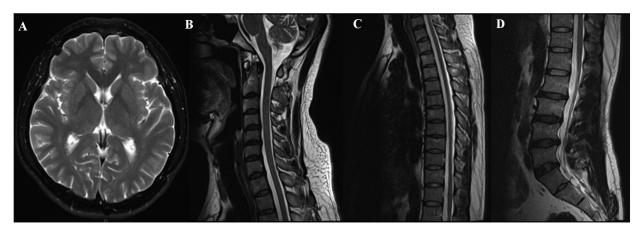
Magnetic resonance imaging of the proband's (A) brain, (B) cervical spine, (C) thoracic spine and (D) lumbar spine did not reveal any obvious pathognomonic alterations.
